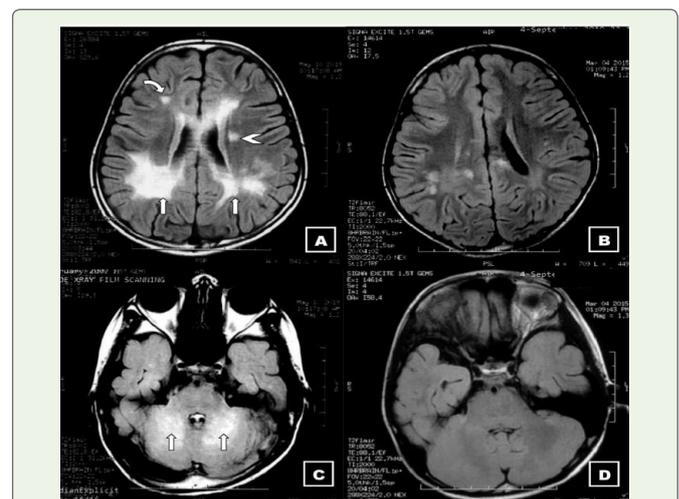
T2 FLAIR axial images of the brain. A) Image at the level of the body of the lateral ventricle shows B/L symmetrical confluent periventricular deep white matter hyperintensities (arrows). A triangular Dawson finger-like lesion was seen in periventricular white matter on the left side (arrowhead). The right frontal lobe shows a small hyperintense focus in subcortical white matter (curved arrow). As compared to the previous scan at the same level (B), the white matter lesions are more extensive. C) Image at the level of the fourth ventricle shows symmetrical hyperintensities in B/L middle cerebellar peduncle, B/L dentate nuclei, and extending into the deep white matter of B/L cerebellum. The previous MRI (D) on comparison showed only mild hyperintensity in the right middle cerebellar peduncle.
